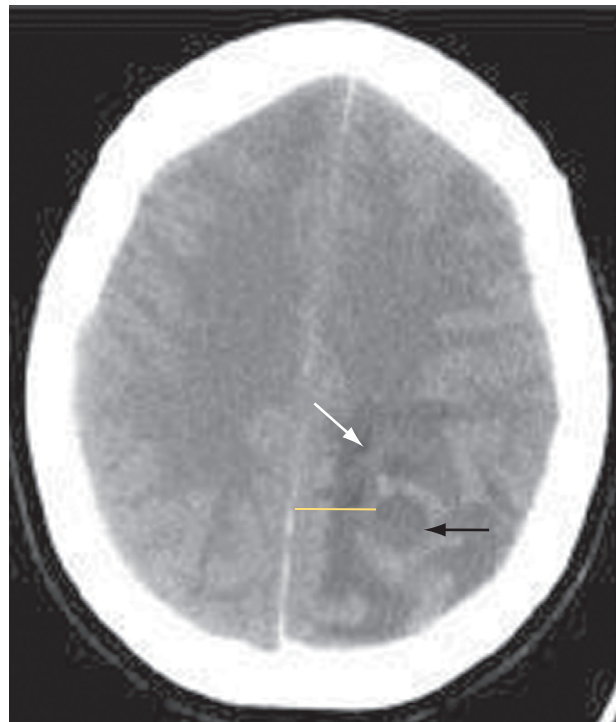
Central nervous system abscess: computed tomography scan of an intraparenchymal abscess (arrows).
